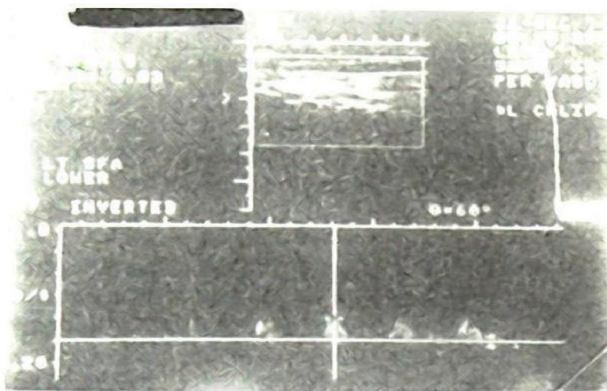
Doppler examination of a normal left CFA showing spectral triphasic velocity waveform. The peak systolic velocity of blood flow in the vessel is 0.69 m/s.
